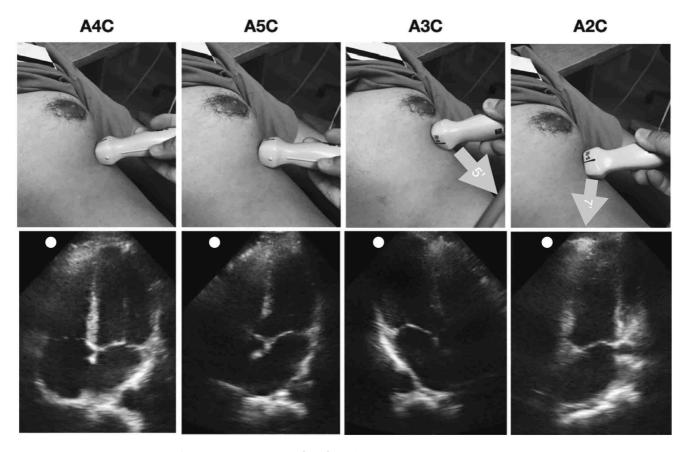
Apical windows. Starting from an apical 4- chamber (A4C) window, tilting more anteriorly will reveal the A5C window. From A4C rotation counter-clockwise to 5 o'clock will reveal apical 3- chamber window, while rotation to 7 o'clock will reveal the apical 2- chamber window. This is with the screen dot on the left side. Note that if the screen dot is on the right side, the scan planes are the same, but the clock positions are flipped (i.e., 7 o'clock to 1 o'clock and 5 o'clock to 11 o'clock).
